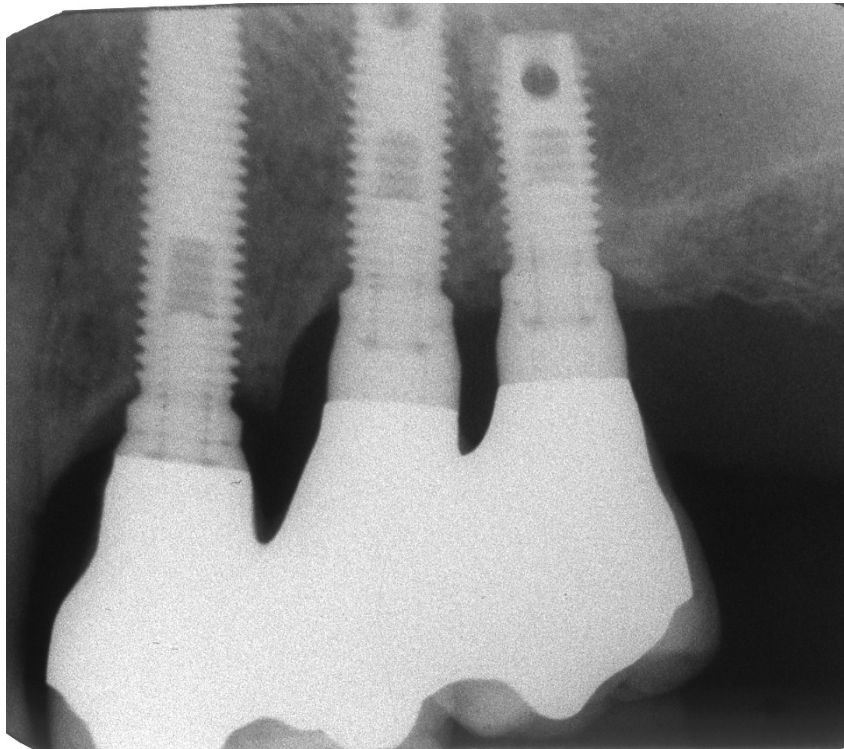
9 year follow-up x-ray shows no further bone loss
